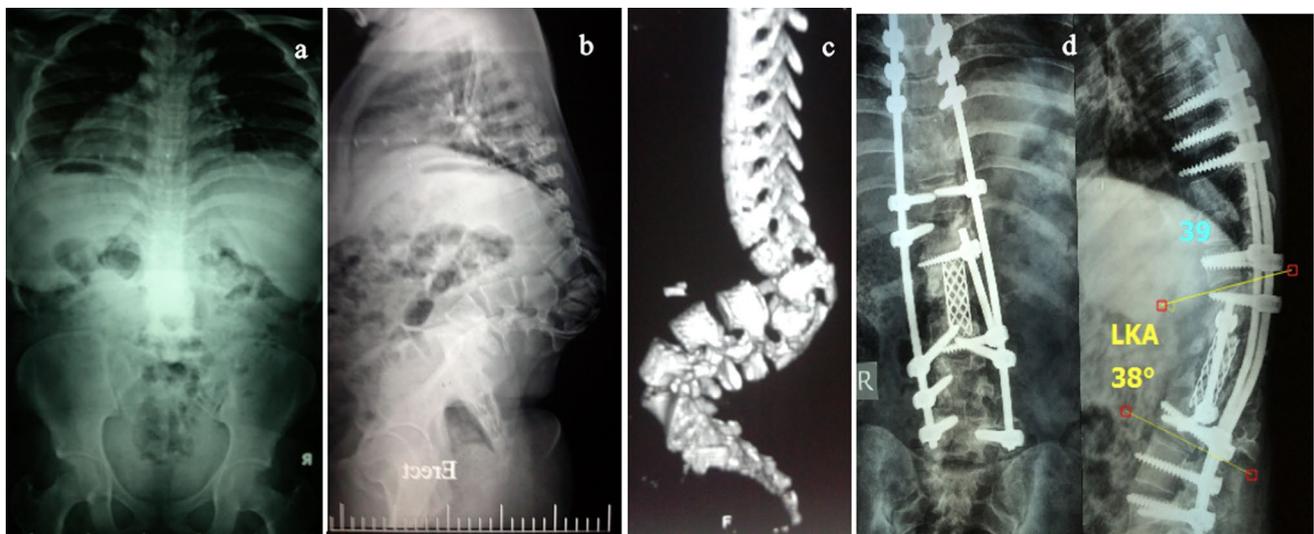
Female patient 17 years old with neglected congenital kyphosis: a, b preoperative AP and lateral X-rays showing severe kyphosis with LKA measuring 129°. c Preoperative sagittal CT scan. d 2-year
